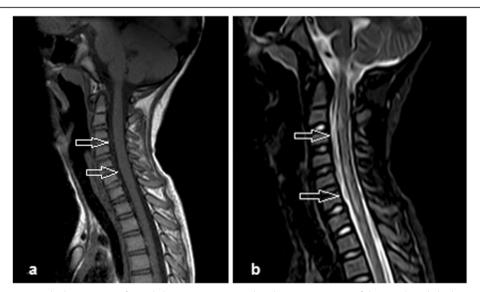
MRI demonstrates multiple segments of signal alteration are seen within the anterior aspect of the spinal cord, the longest seen opposite C4 down to D1 levels. These elicit low to intermediate sagittal T1W signal (a) and sagittal bright T2W signal (b) and with associated mild cord expansion
